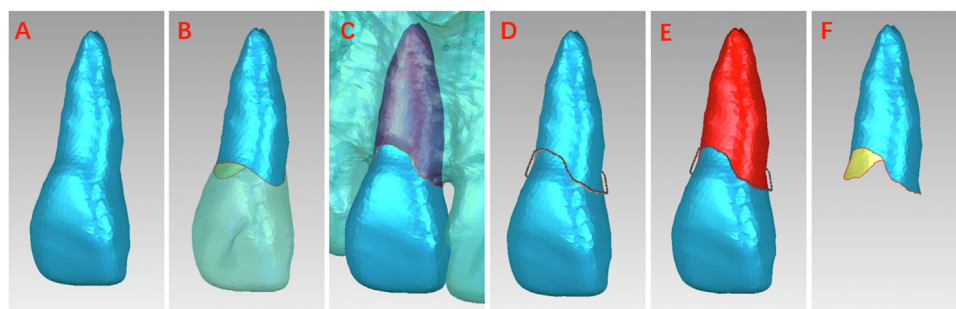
Separation of RSA and PDL_Area: A, 3D digital tooth model generated from CBCT; B, The model was separated along the CEJ curve, and RSA was obtained; C, The periodontal alveolar attachment level was drawn around the incisors on the bone model; D, The curve on the bone model was projected to the tooth model; E, The tooth model was separated along the periodontal alveolar attachment curve, and the PDL was obtained; F, The crown was removed, and PDL was preserved.
